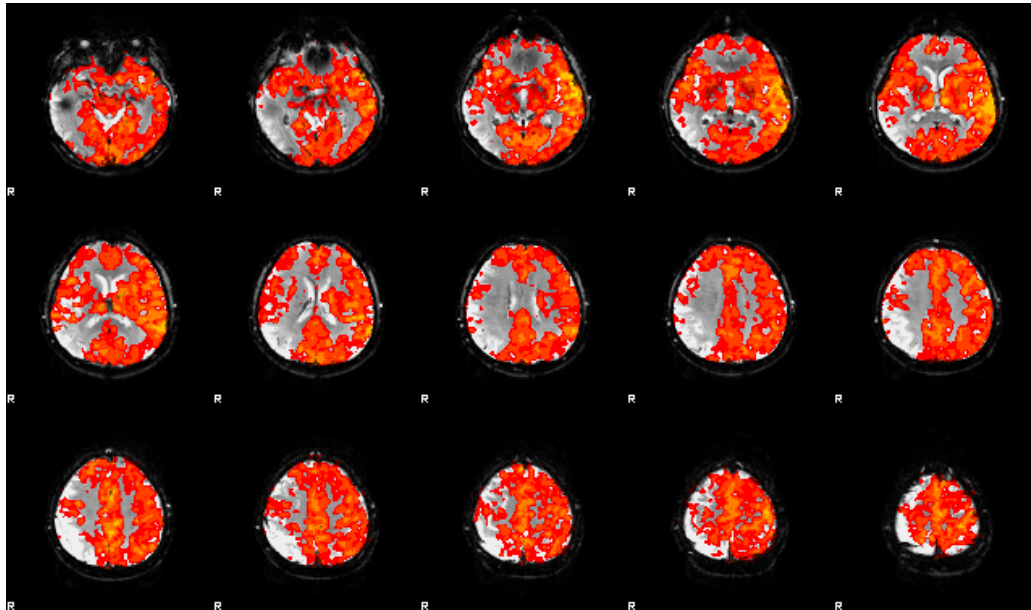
Activation Map of the pt 11 (male, 64 y.o.), affected by right MCA severe stenosis (see fig. 3A), who performed TCD that resulted not diagnostic because of aliasing artifacts. In this case f-MRI demonstrated CVR impairment of the right hemisphere, ipsilateral to the stenosis.
